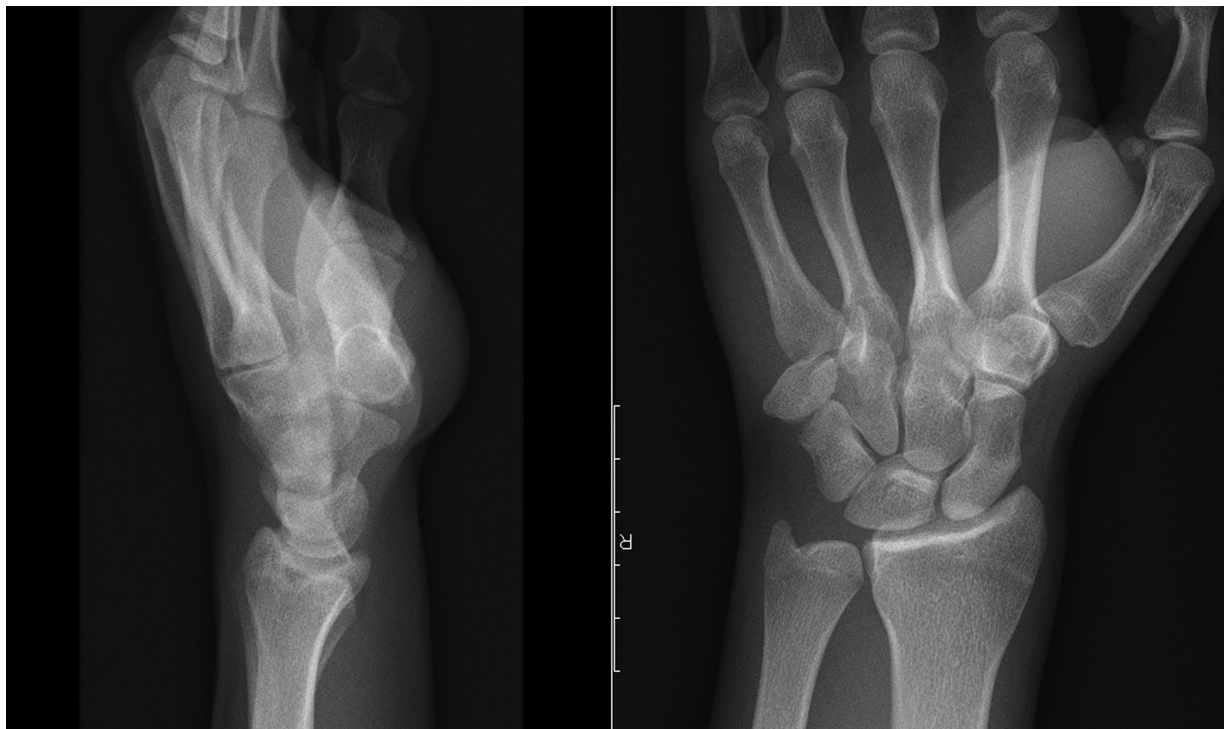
Initial radiograph demonstrating a distal pisiform dislocation.
